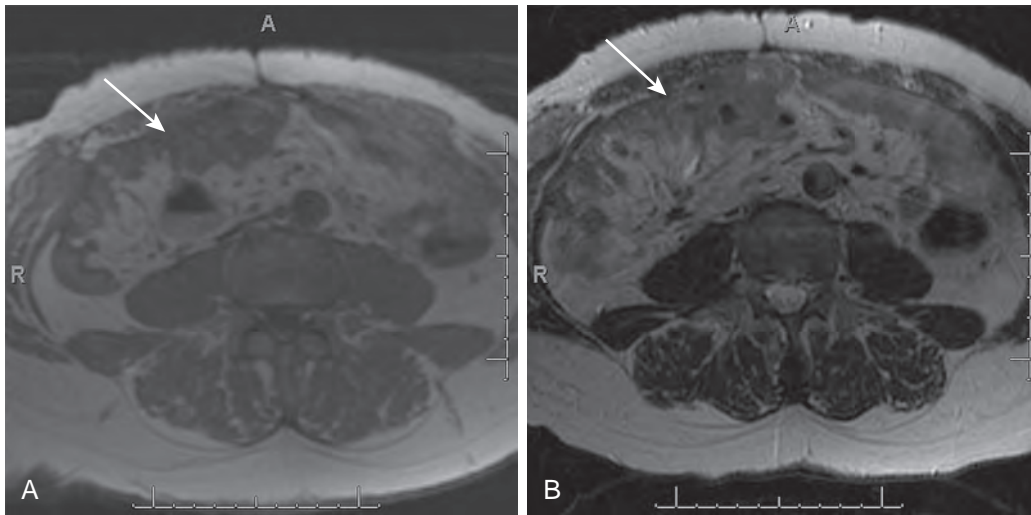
Peritoneal mesothelioma on MRI. Axial T1-weighted (A) and axial T2-weighted (B) images demonstrating infiltrative mass (arrow) involving the mesentery and omentum.
